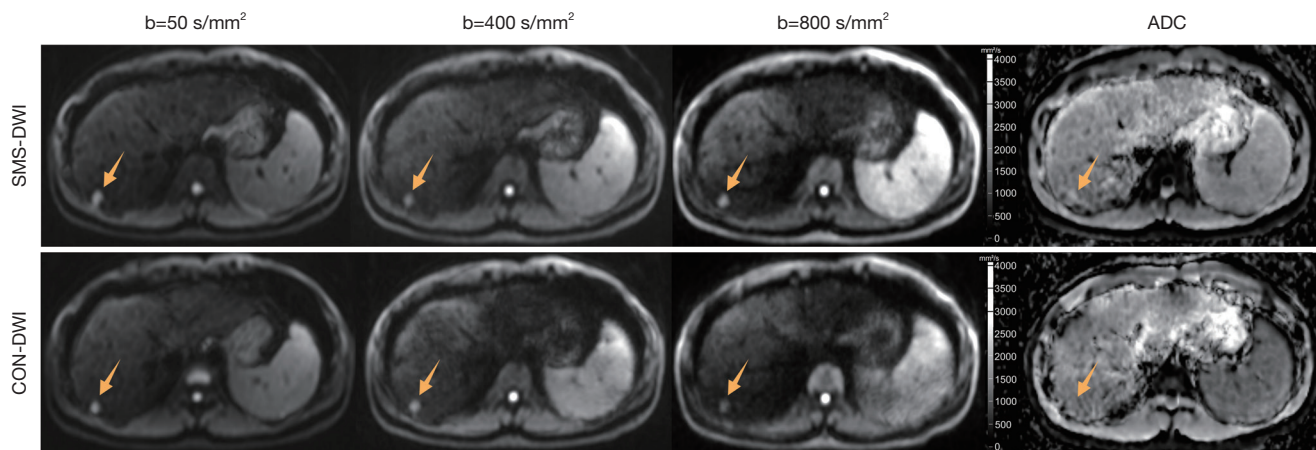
Representative images with SMS-DWI (upper row) and CON-DWI (lower row) of a 29-year-old male patient with pathologically confirmed hepatocellular carcinoma. Diffusion-weighted trace images with three different b-values ($b=50$, $b=400$, $b=800$ s/mm²) and the corresponding ADC maps are shown, with the arrows pointing to the lesion. The average ADC measurements were 1.08×10^{-3} mm²/s in SMS-DWI and 1.11×10^{-3} mm²/s in CON-DWI. SMS, simultaneous multislice; DWI, diffusion-weighted imaging; ADC, apparent diffusion coefficient; CON, conventional.
